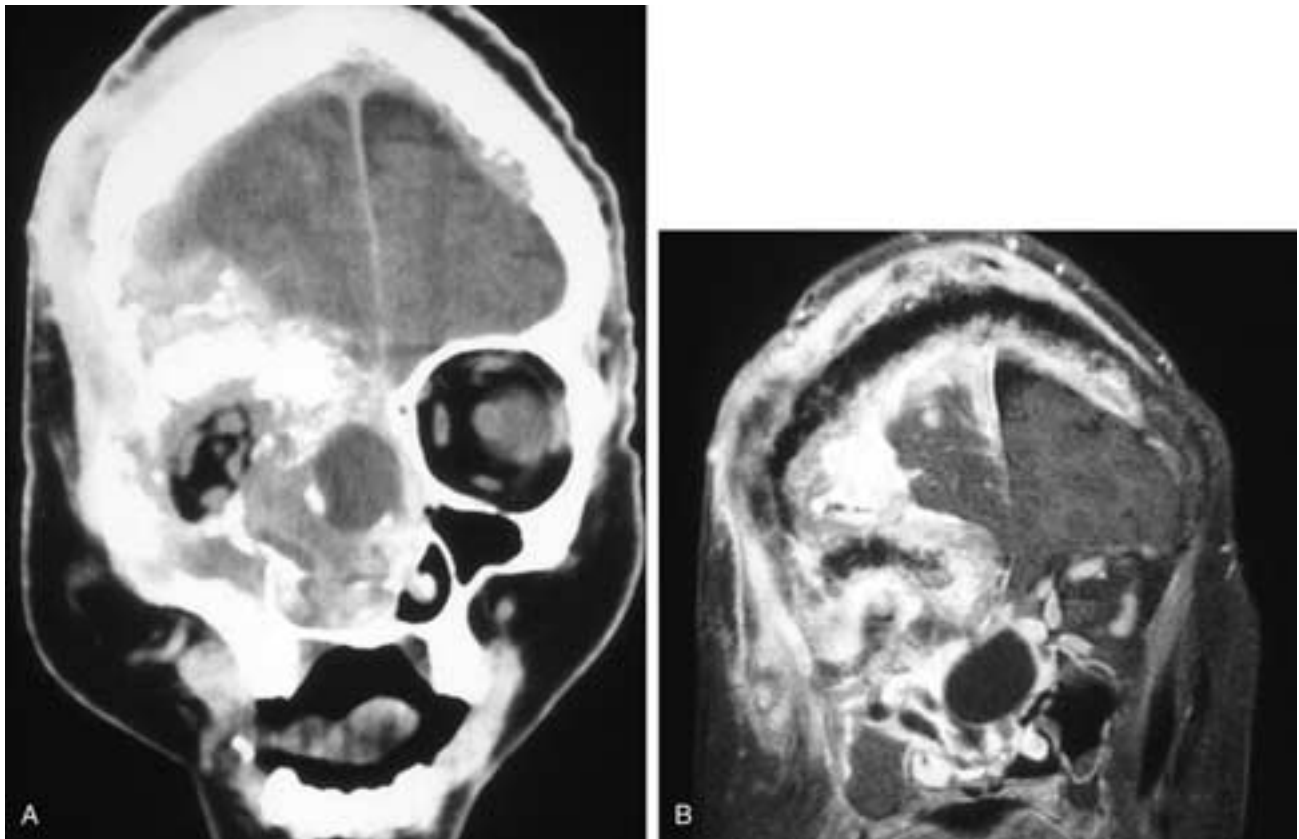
Coronal contrast-enhanced CT scan (A) and coronal T1-weighted, fat-suppressed, contrast-enhanced MR image (B) show a highly destructive tumor involving the nasal cavity, the right ethmoid and maxillary sinuses, the orbit, the right calvaria, dura, brain, and scalp. This highly aggressive tumor growth would be unusual for a typical squamous cell carcinoma. This patient had an adenosquamous carcinoma.
